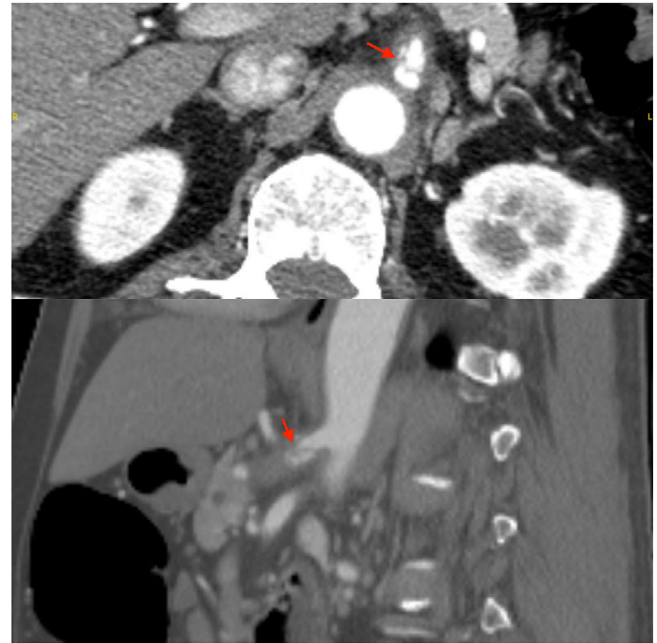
Computed tomography angiography showing a filling defect (red arrow) in the celiac artery in the top, coronal image and the bottom, sagittal image.
